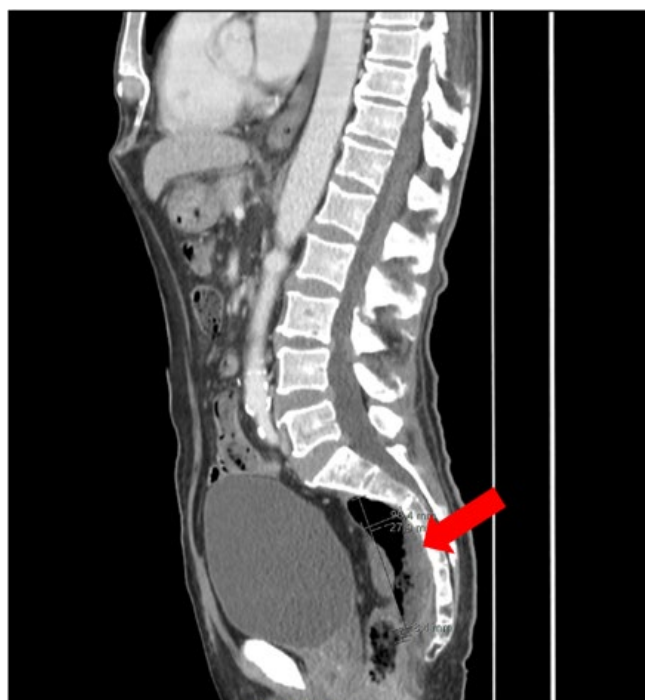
Sagittal section of abdominal computed tomography (CT) with presacral collection measuring about 90 x 66 x 28.
